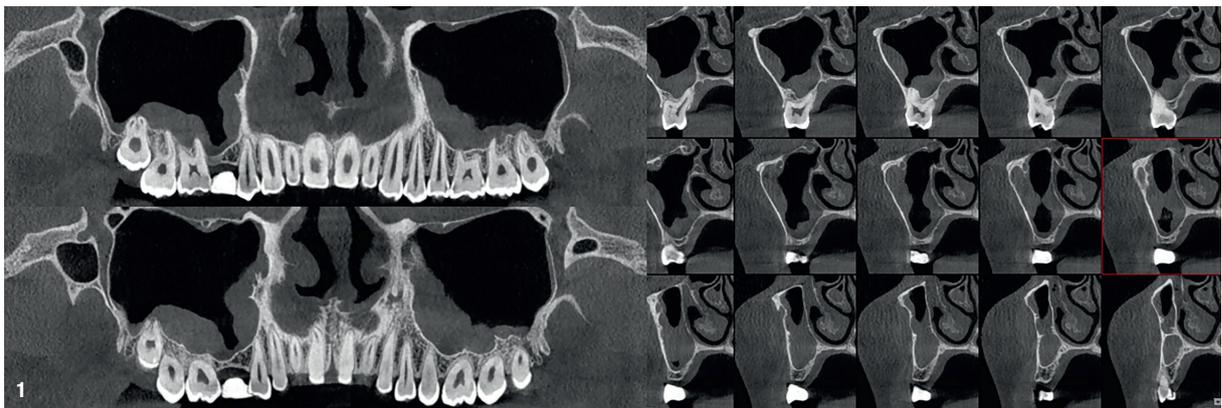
Initial CT scan with coronal and sagittal sections.
